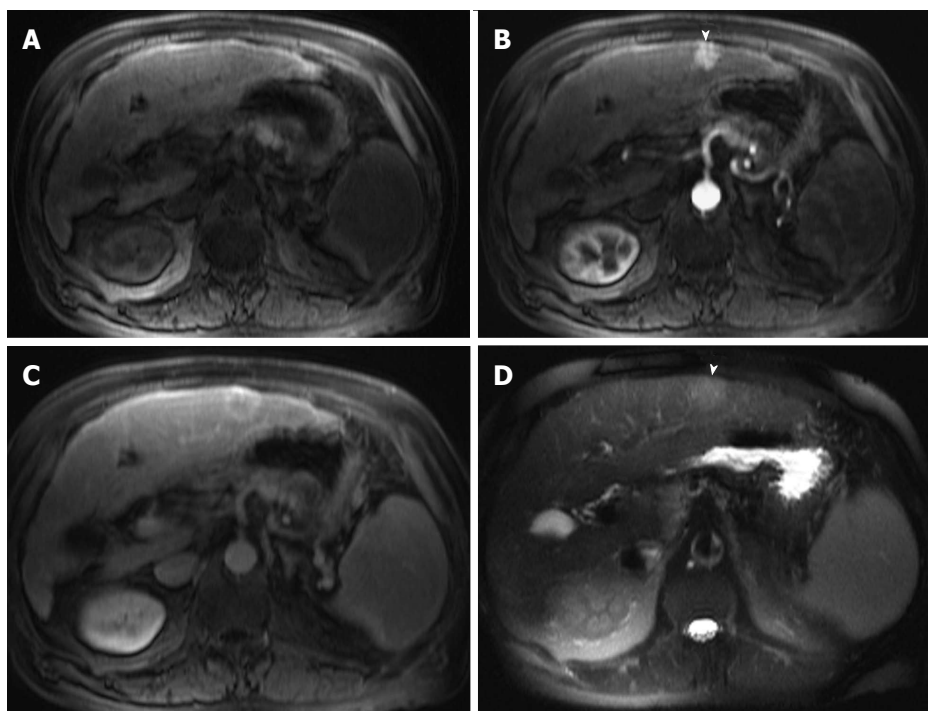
Classical hepatocellular carcinoma. A: Pre- and post-contrast fat-suppressed 3D-GRE T1-weighted images during the late hepatic arterial (B) and delayed phases (C); D: Fat-suppressed SSFSE T2-weighted image. There is a peripheral well defined left hepatic lobe nodule, which demonstrates iso T1 signal intensity (A), increased arterial enhancement (arrowhead, B), delayed washout and pseudocapsule enhancement (C), and mildly increased T2 signal (arrowhead, D) in keeping with classical features of HCC. HCC: Hepatocellular carcinoma; GRE: Gradient recalled echo; SSFSE: Single-shot fast spin-echo.
